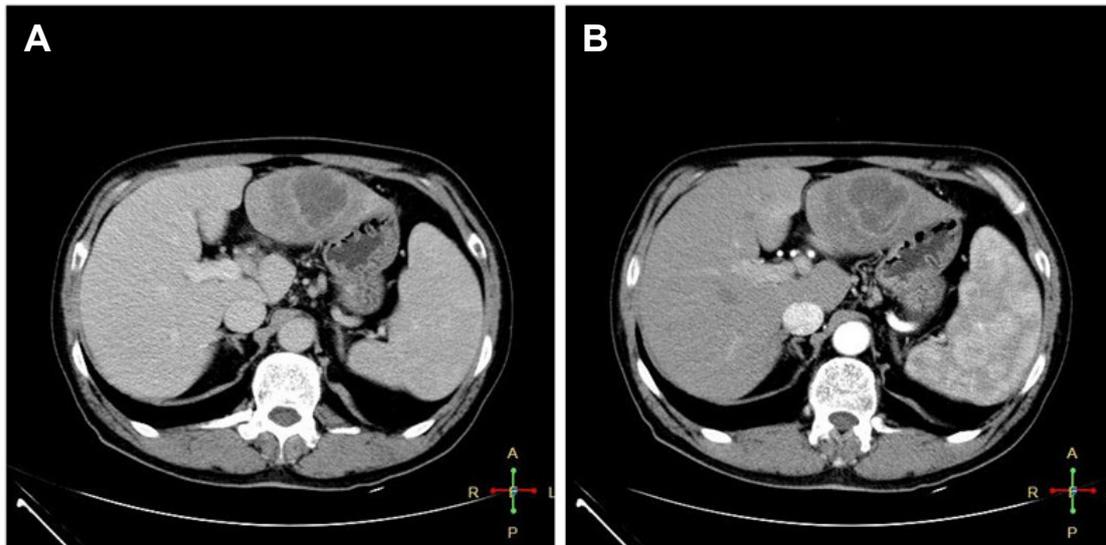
Computed tomography images of the abdomen. (A) A well-defined heterogeneous mass 4.0 cm × 4.0 cm in size was situated in the left hepatic lobe. (B) The lesion featured central necrosis, a hyper-dense rim, and mild enhancement starting in the arterial phase.
